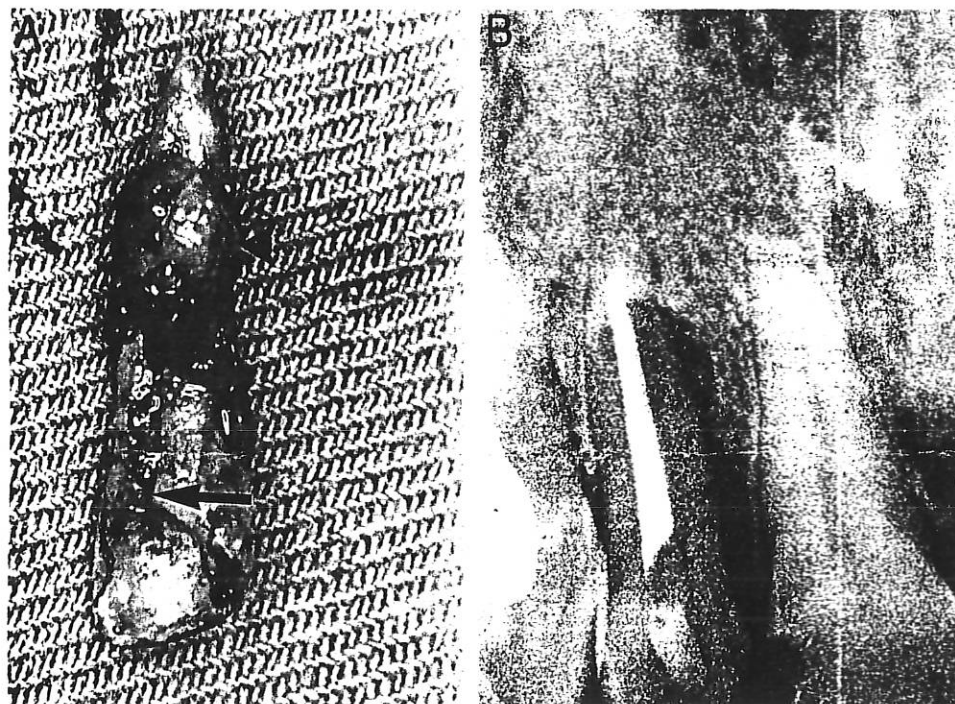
A) Tooth #10 immediately after extraction, demonstrating a palato-gingival groove from the cingulum area (arrow) to a pea-sized granuloma near the apex (arrowhead). B) Radiograph showing a distinct intrabony defect on the palatal and mesial aspect of tooth #10.
